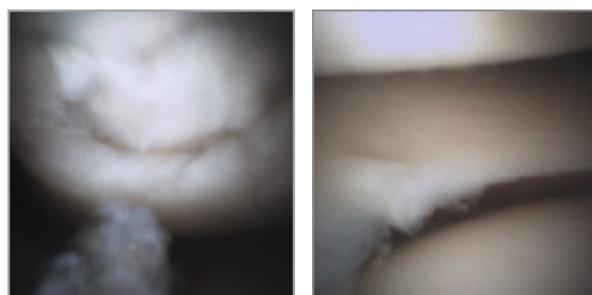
Chondral lesion and lateral meniscus tear visualized via mi-eye 2™ previously not detected by MRI
